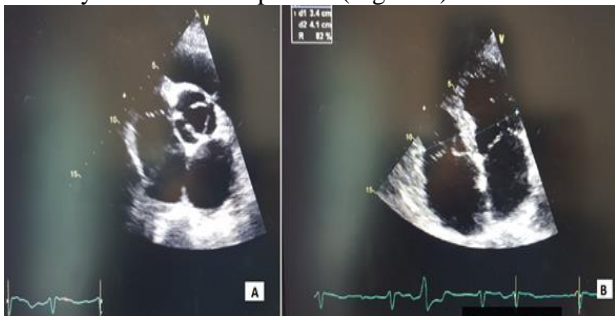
transthoracic echocardiography a month later.absence of right atrial thrombus.
